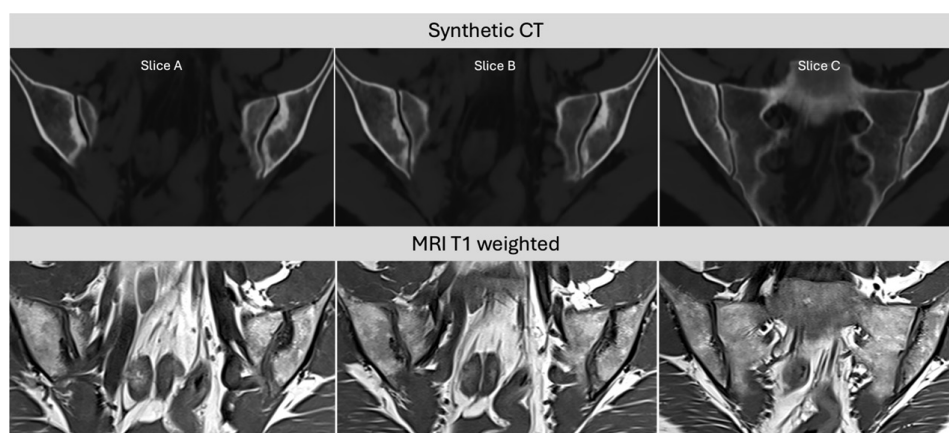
Comparison of sCT and MRI T1-weighted sequences. Although sclerosis was scored on sCT, MRI sclerosis did not reach ≥ 5 mm in depth and was, therefore, not accounted for on MRI. sCT, synthetic CT.
